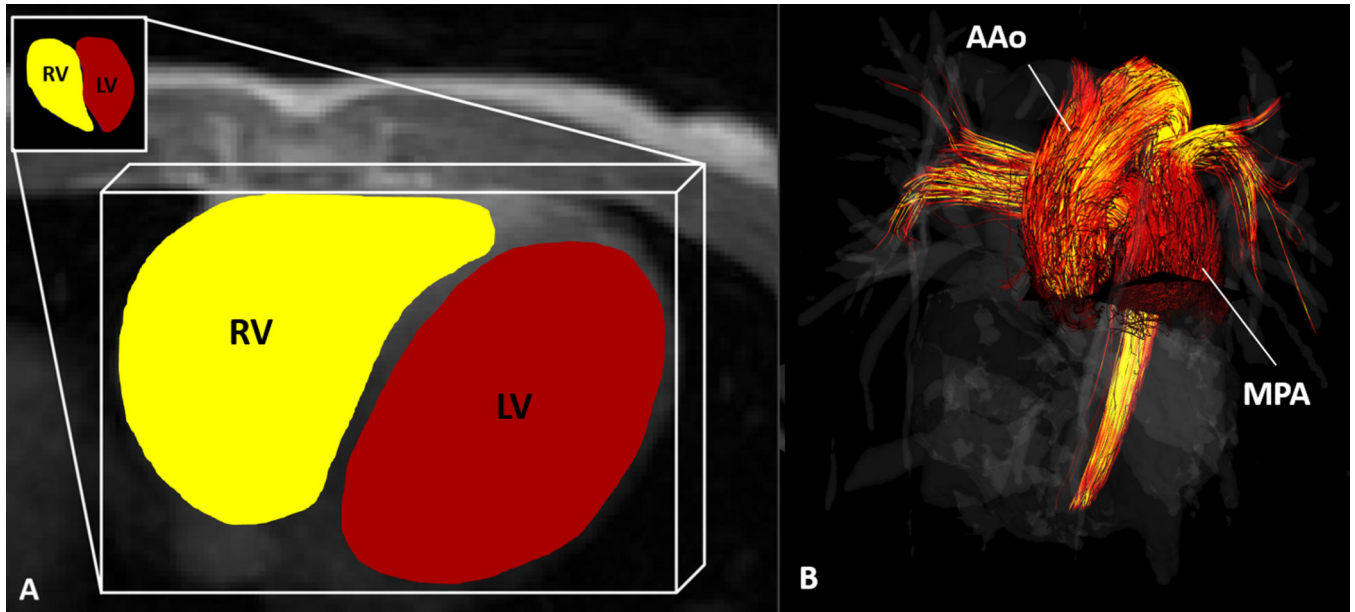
4D Flow MRI was used to calculate (A) kinetic energy in the right (RV) and left (LV) ventricles of healthy volunteers and in the single ventricles of Fontan patients. (B) flow through the main pulmonary artery (MPA) and ascending aorta (AAo) in healthy volunteers and the AAo in single ventricle patients.
